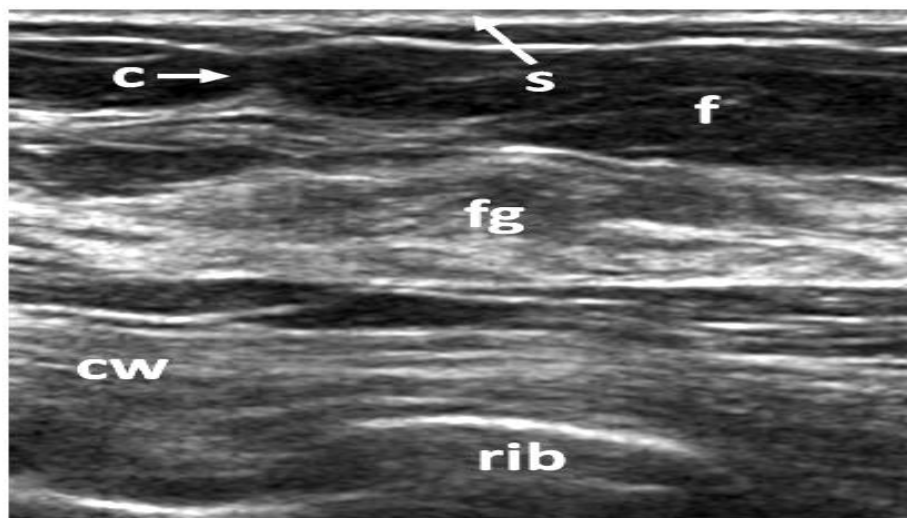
Normal ultrasound breast anatomy. The breast is covered by hyperechoic skin (s) within the breast is fat (f) and fibroglandular tissue (fg). Cooper ligaments (c) and chest wall (cw) with visible ribs (Jesinger, 2014).
